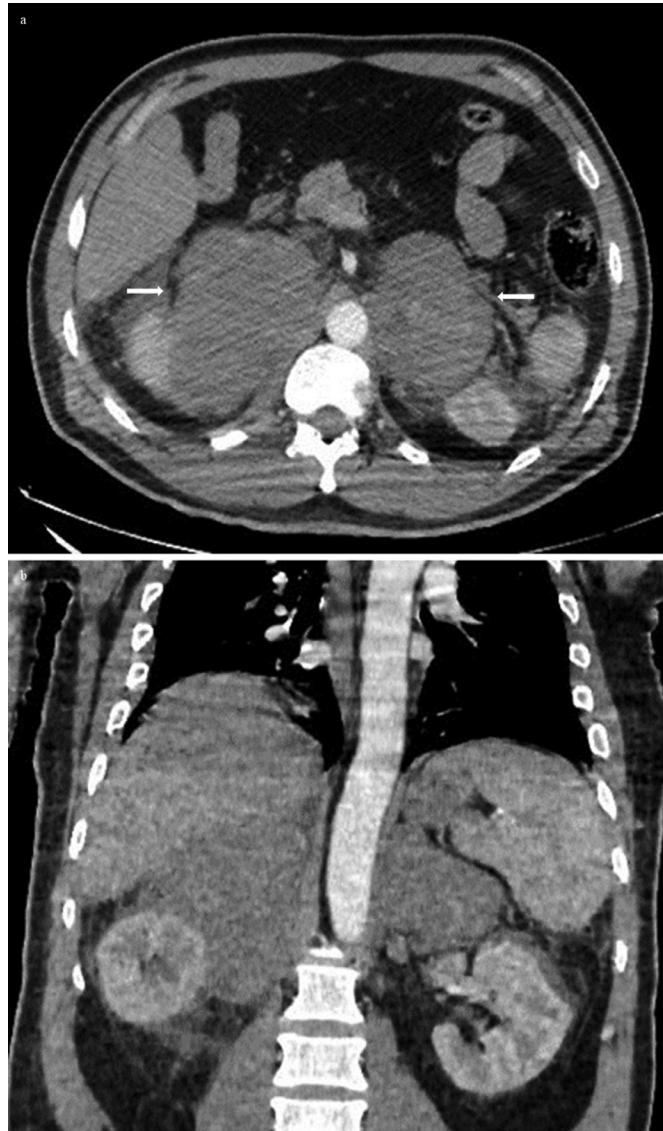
Postcontrast CT scan axial (A) and coronal (B) images showed bilateral adrenal masses which are homogenous with a slight contrast enhancement measuring 114 x 91 x 78 mm on the left (77.4 average HU), while the right adrenal gland measures 130 x 103 x 91 mm (73.7 average HU).
